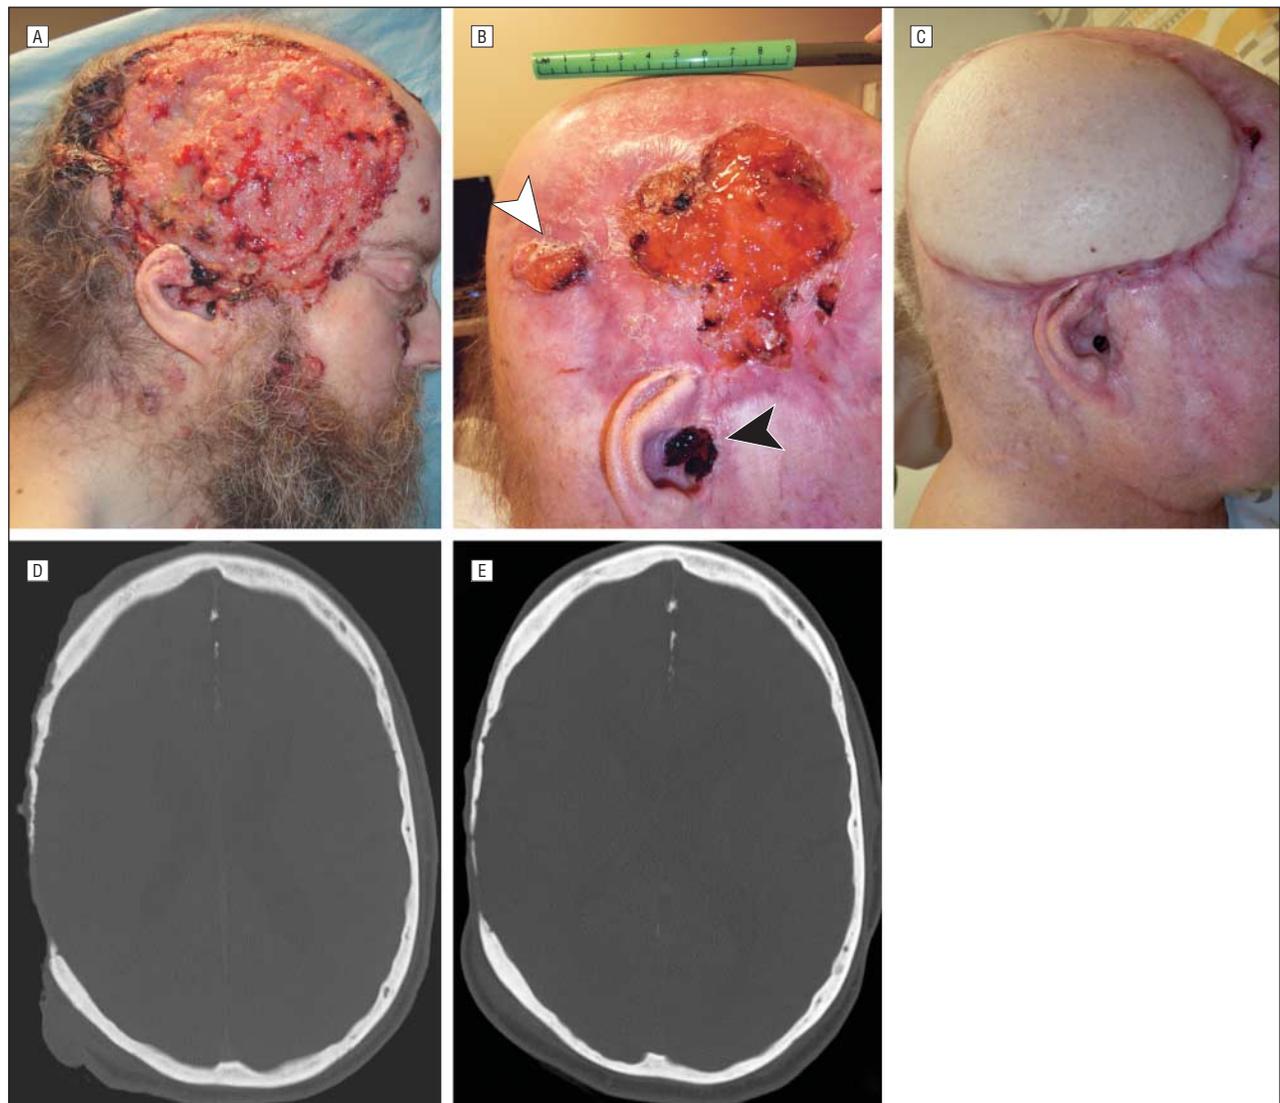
Clinical and computed tomographic (CT) images of a 55-year old man with Gorlin syndrome. The patient's locally advanced basal cell carcinoma (BCC) regressed under treatment with neoadjuvant vismodegib but demonstrated areas of drug resistance. Residual BCC and resistant areas were excised. A, Locally advanced BCC on the right scalp prior to treatment. B, Tumor shrinkage after 51 weeks of vismodegib therapy showing development of 2 areas of resistant BCC (arrowheads). C, After surgical excision, the patient received full-thickness skin grafts to cover the right scalp and the right tragus/external auditory canal, shown here at 2 months after surgery. D, Pretreatment axial CT image shows bony defects of the calvarium under the BCC. E, Posttreatment CT scan shows shrinkage of the calvarial defect after vismodegib therapy.
